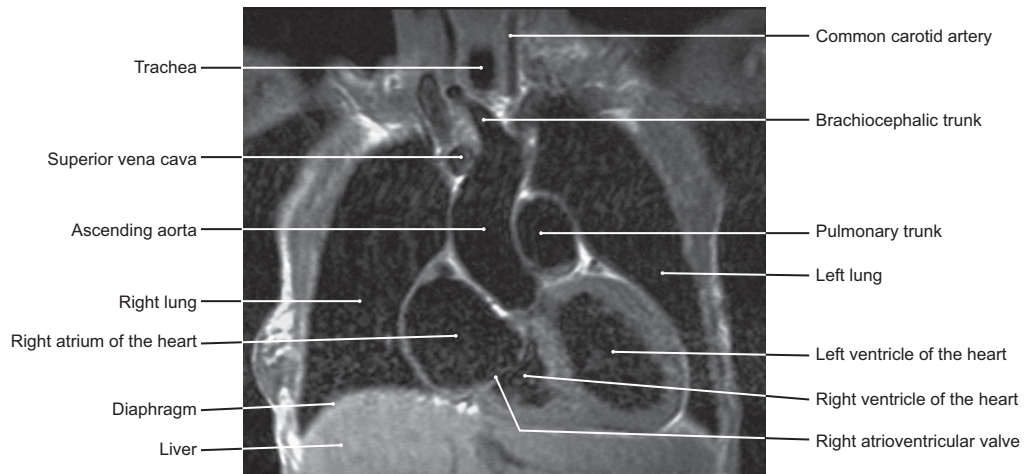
MRI of Thorax at the Level of the Superior Vena Cava (Anterior View)
